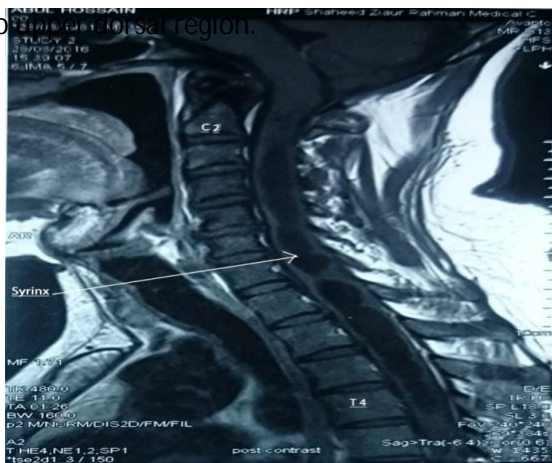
MR images showing a large cervico dorsal syrinx
